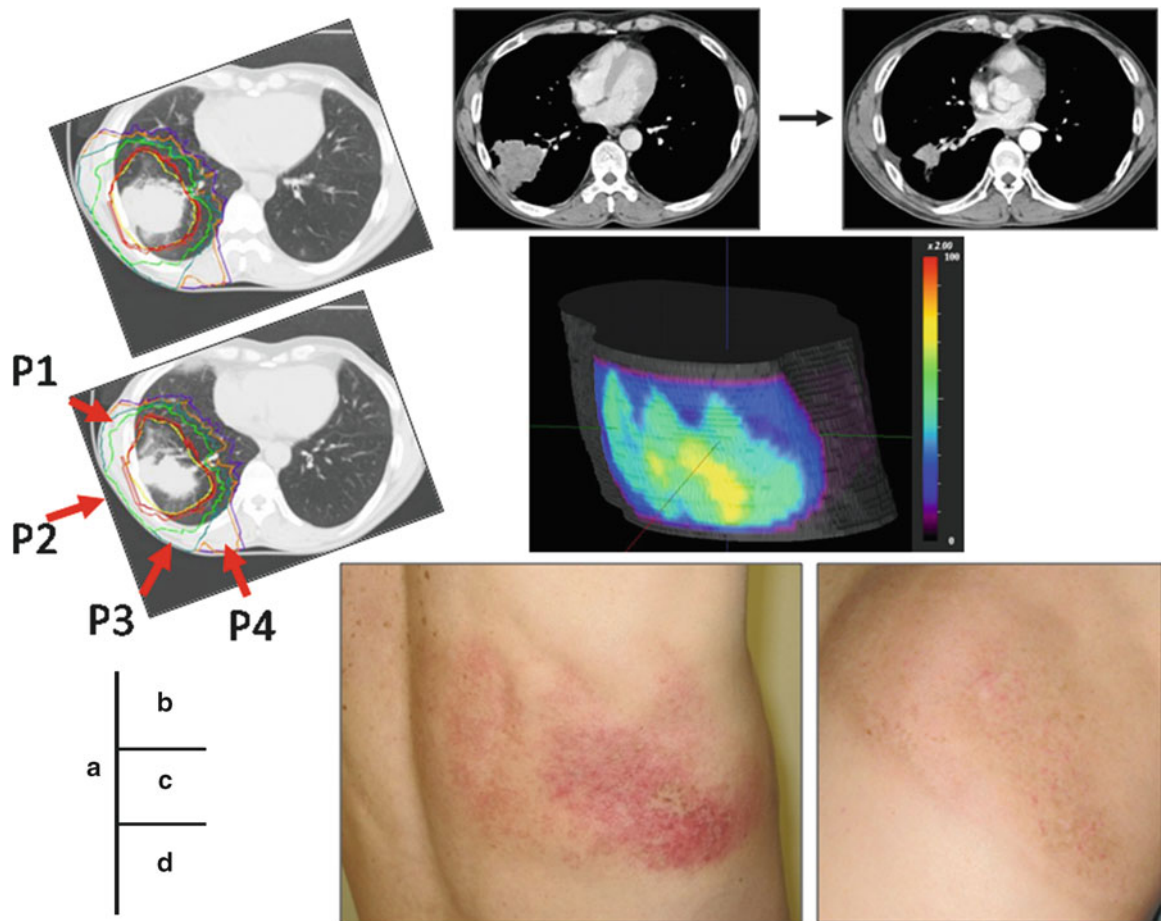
(A) The Dose distribution for a tumor receiving a total carbon ion dose of 44.0 GyE from four directions. (B) CT images before and after treatment. Four months after the treatment, the tumor showed a partial response (PR). (C) The body surface model of the planning
